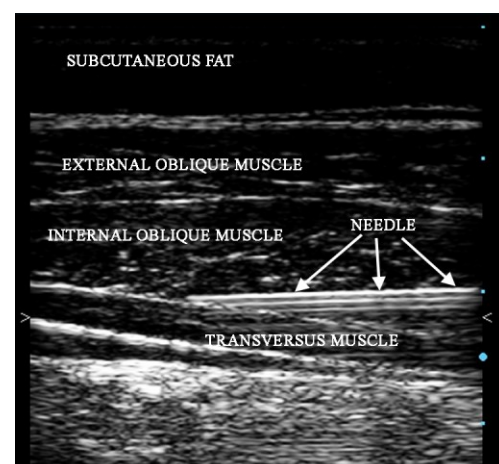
TAP block needle approaching the plane in the lateral abdominal wall, the lateral skin of the abdomen is to the top of the sonogram as it appears on the screen.
